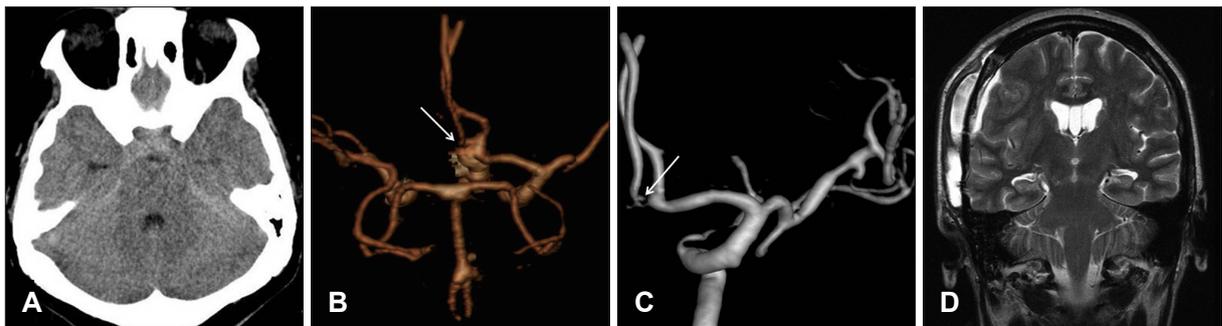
Radiological findings of case 2. A: Head computed tomography (CT) showing subarachnoid hemorrhage of Fisher's grade 2. B: Cerebral CT angiography. Arrow indicates anterior communicating artery aneurysm. C: Postoperative cerebral angiography indicating no residual aneurysmal sac or vascular abnormality. D: Brain magnetic resonance image demonstrating a small amount of fluid collection over the right frontotemporal convexity with unremarkable brain stem area.
